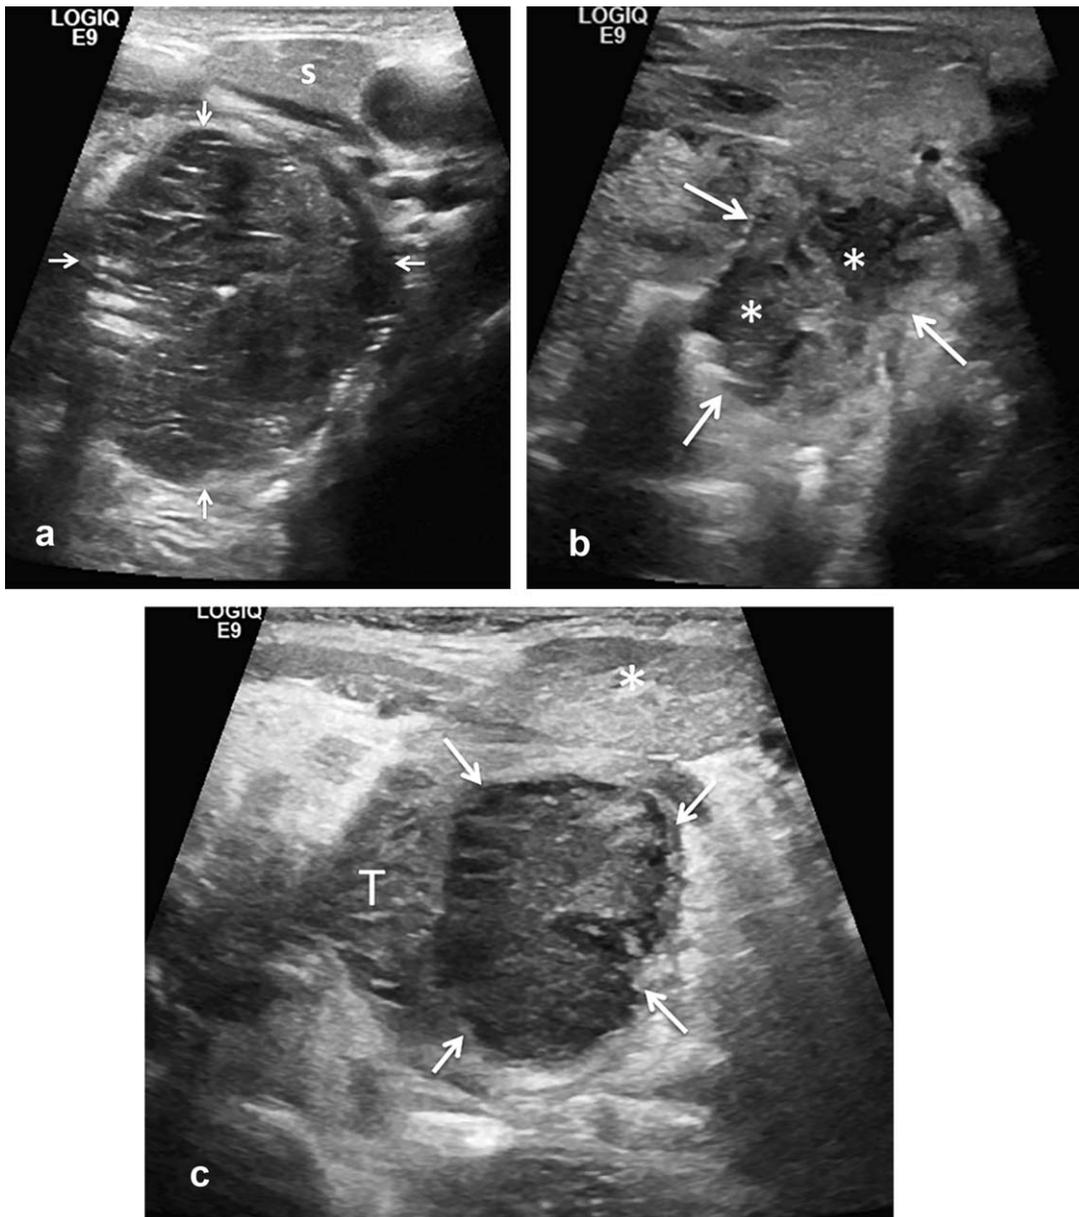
(a) Transcervical ultrasound showing an example of left acute tonsillitis. Arrows delineate periphery of the tonsil. (b) Transcervical ultrasound showing an example of left peritonsillar phlegmon with developing small intratonsillar abscesses (*). Arrows show ill-defined margins and markedly increased echogenicity of surrounding soft tissues that suggests significant inflammatory change. (c) Transcervical ultrasound showing an example of left peritonsillar abscess, which is lateral relative to the T and deep to the submandibular gland (*). S = submandibular gland; T = tonsillar tissue.
